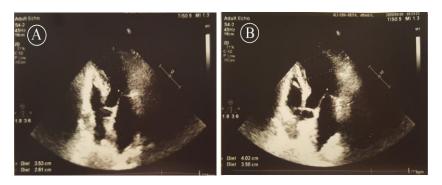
Echocardiogram showing ventricle at the end of systole (A) and at the end of diastole (B)
